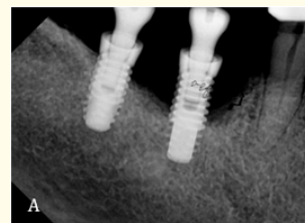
and 9B: Initial condition, RX Periapical imaging, clinical.
